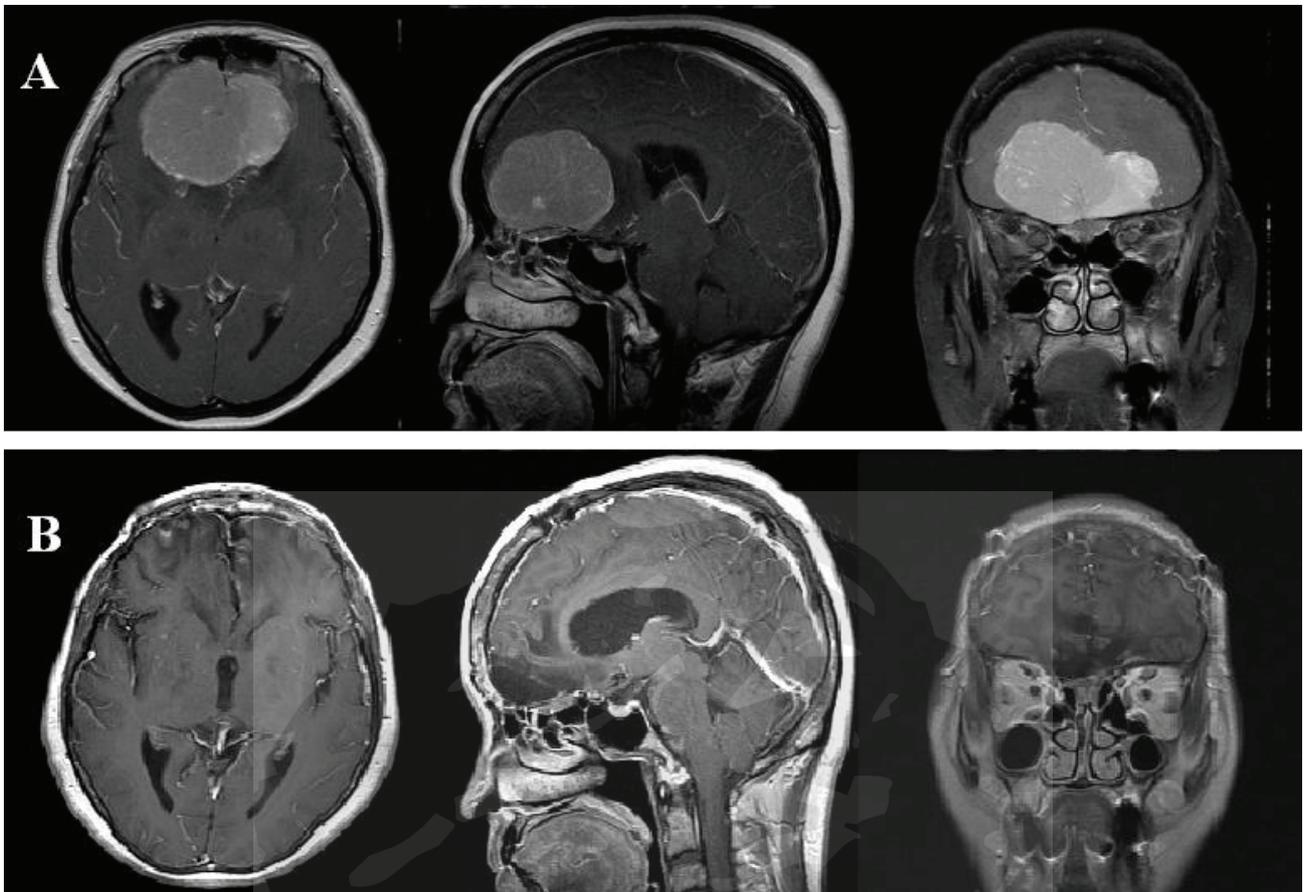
A, MRI scan with gadolinium enhancement revealing a large olfactory groove meningioma. B, postoperative MRI scan with gadolinium enhancement showing no evidence of tumor recurrence 2 years after resection
